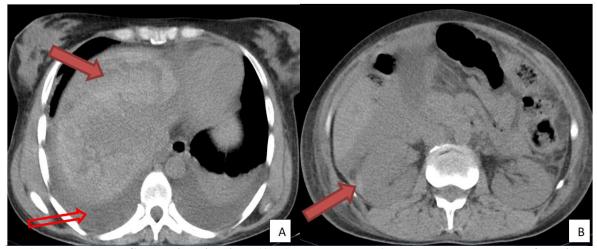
Non enhanced CT scan in axial views (A, B) demonstrates: A subscapular hematoma of the liver and right renal hematoma associated with bilateral pleural effusion
